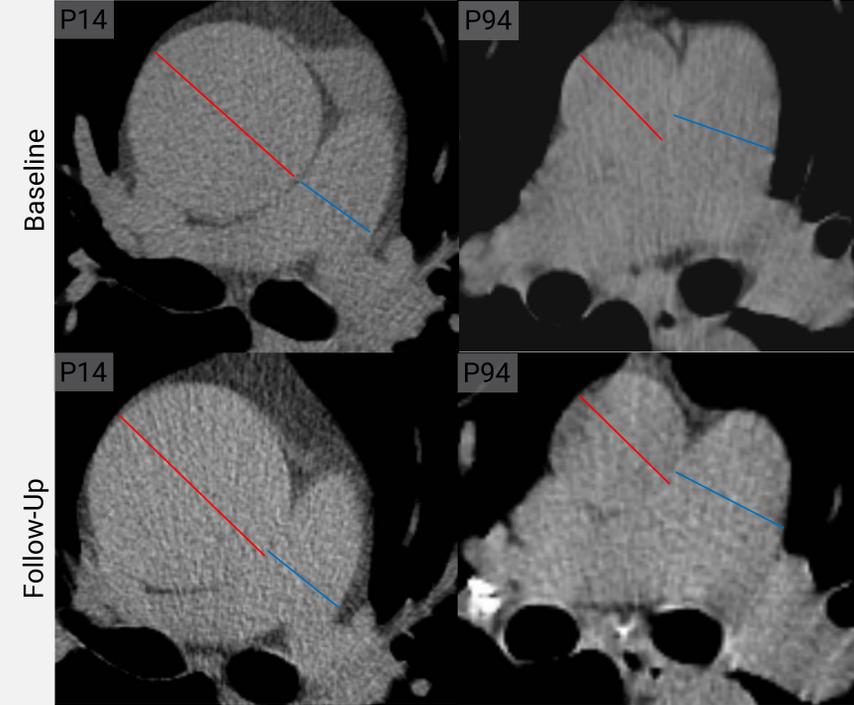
Measurements of PA:Ao acquired using CT in ex-smokers with and without COPD at baseline and follow-up. Red line denotes aorta diameter and blue line denotes pulmonary artery diameter.
